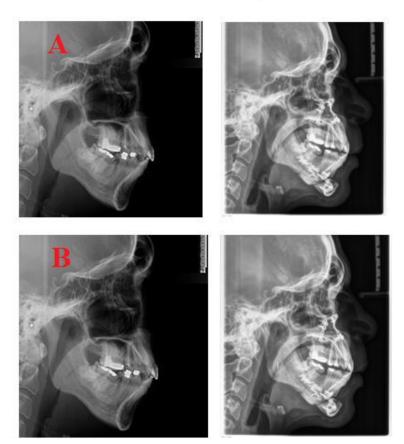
Cephalometric X-ray (A) pre- and (B) post-operative following MMA demonstrating change in pharyngeal airway volume
